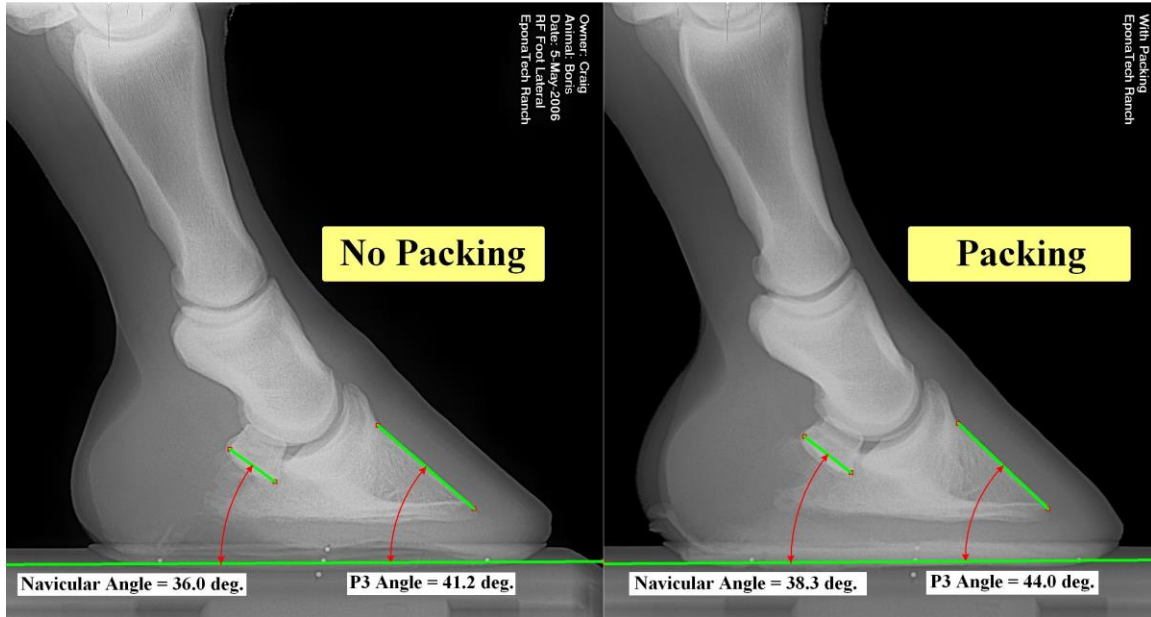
The addition of packing changes internal stance of the pedal bone. Note the difference in angles between the left radiograph (the sole is not packed) and the right radiograph (the sole is packed.) Note that this radiograph is that of the hoof in figure 2A.
